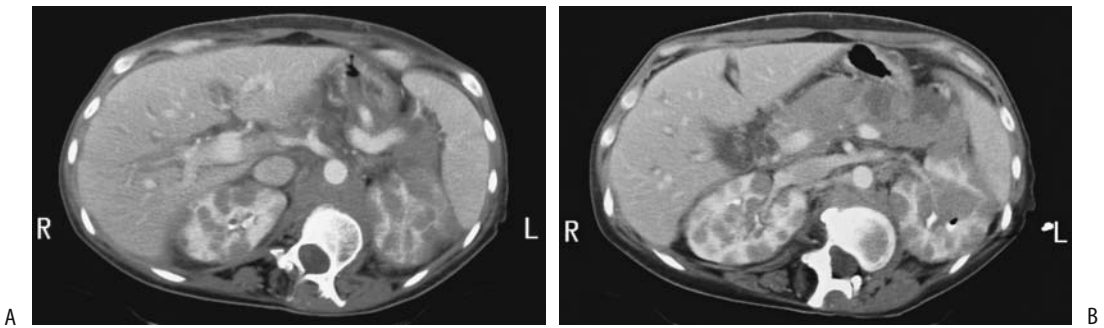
Abdominal lymphoma. A,B: Two contrast-enhanced CT images reveal an enlarged pancreas, encased great vessels and numerous renal tumors. (Courtesy of Patrick Fultz, M.D., University of Rochester.)
